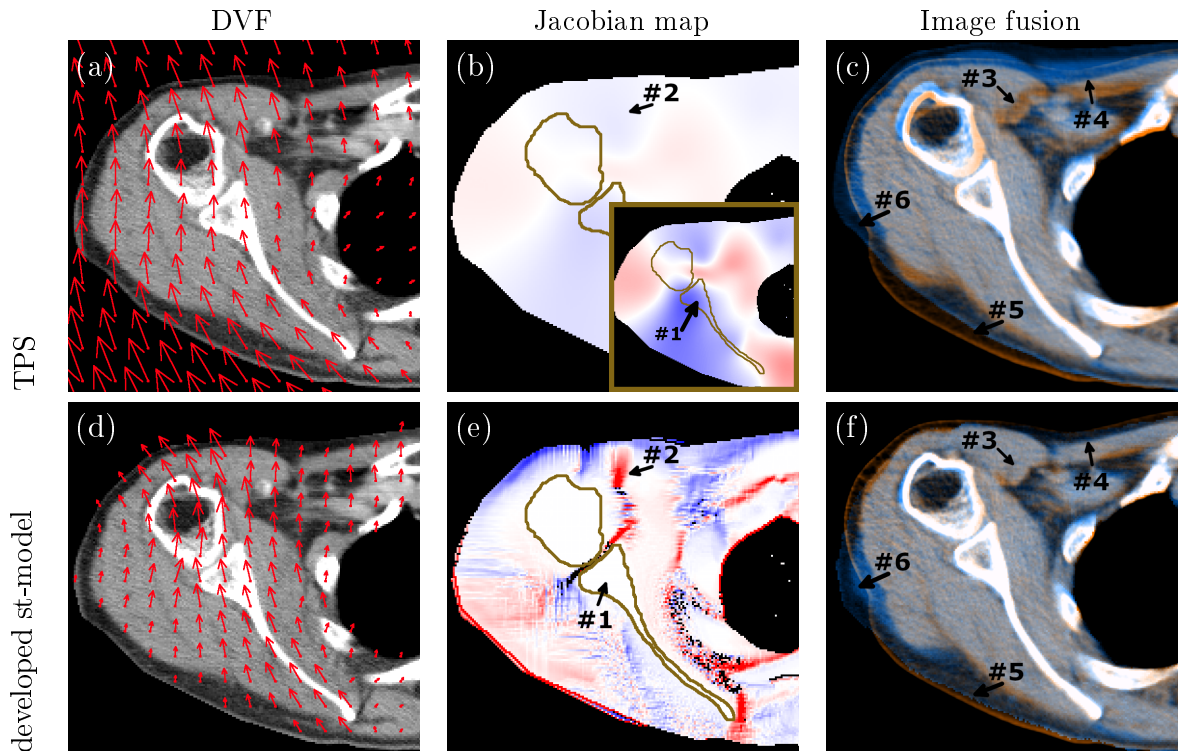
Comparison of the deformation results for the thin-plate splines (upper, row) and the final version of the developed soft-tissue model (lower row), for patient 1. For both models, the DVF overlaid on the planning CT (first column), the corresponding Jacobian maps (second column), as well as the artificially deformed images (third column) are shown. The inlay in (b) shows the same Jacobian map, but with the width of the color-scale narrowed to one fourth of the original scale. Arrow 1 marks the Jacobian values within bones, which are not volume conserving for the TPS. Arrow 2 marks borderline irregularities, which only occur in the developed soft-tissue model. Arrow 3 marks areas in which the soft-tissue alignment is improved, arrows 3 and 4 areas, in which the deformation of the patient outline is improved, by the developed soft-tissue model. Arrow 6 marks misalignment of the patient outline, which occurs in both models.
